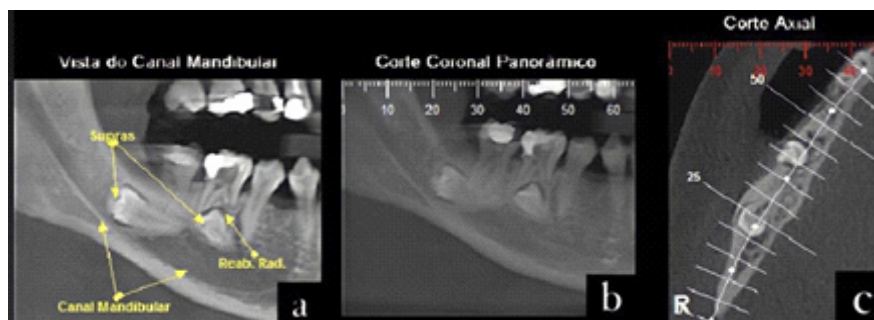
Cone-Beam Computed Tomography: (a) view of the mandibular canal; (b) panoramic coronal section; (c) axial section.
